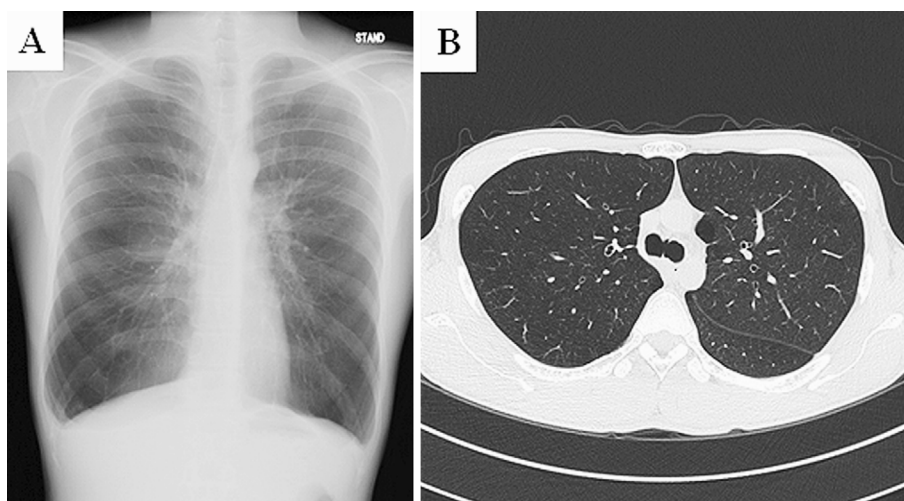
Posterior-anterior chest radiograph (A) and high-resolution computed tomography (HRCT) of the thorax (B). Chest radiograph showed hyperinflated lung fields with a low-lying diaphragm and a tear drop heart. HRCT showed diffuse low attenuation areas throughout the lung fields.
